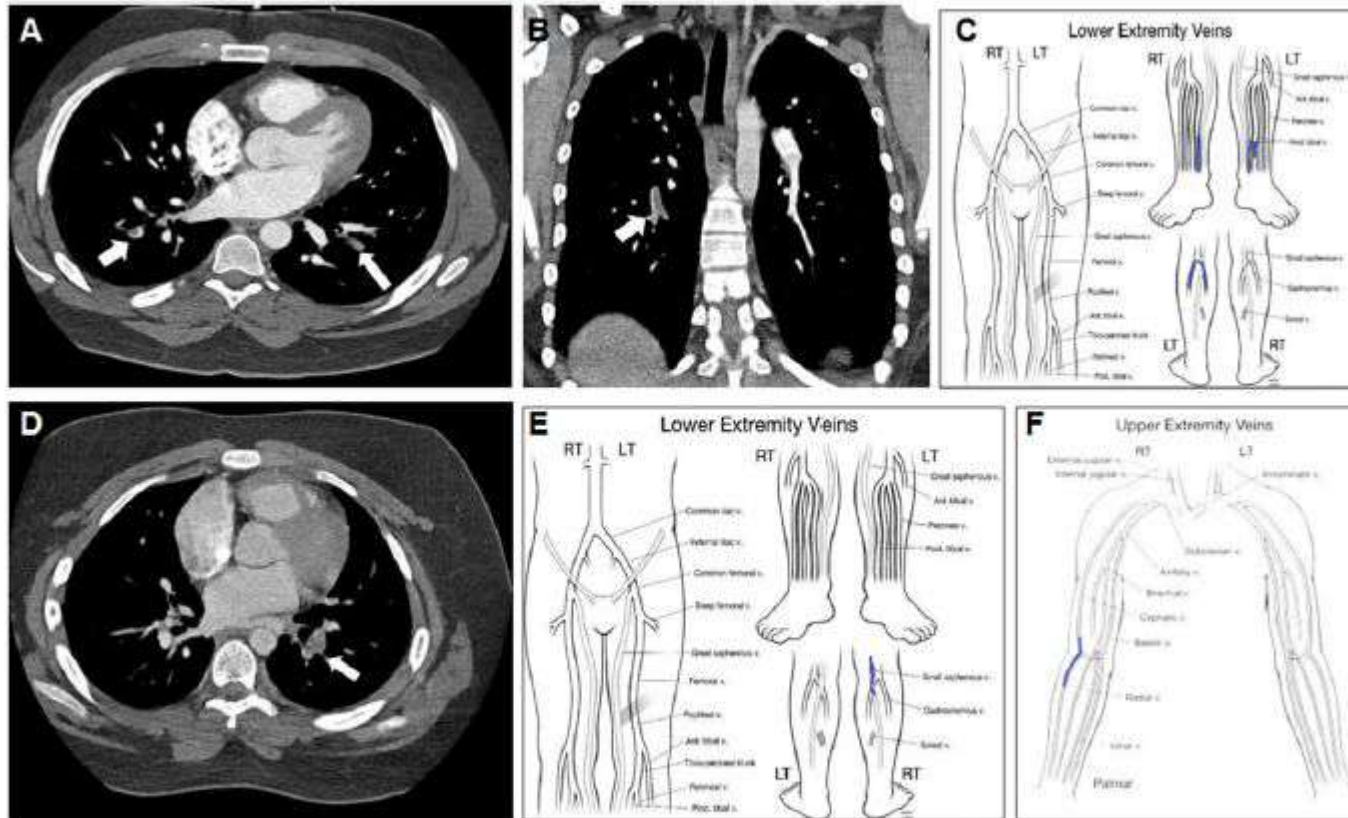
(A) Chest CT, axial view, revealing a pulmonary embolism (arrows) in case 2.1. (B) Chest CT scan, coronal view, revealing an acute right pulmonary artery embolism (arrow) in case 2.2. (C) Lower extremity mapping computed from ultrasound revealing thromboses in bilateral posterior tibial veins and left upper calf gastrocnemius vein (case 2.2). (D) Pulmonary embolism on chest CT scan in case 2.3 (arrow). (E) Lower extremity mapping computed from ultrasound revealing a right saphenous vein thrombus in case 2.3. (F) Upper extremity mapping demonstrating bilateral cephalic vein thromboses in case 2.3
